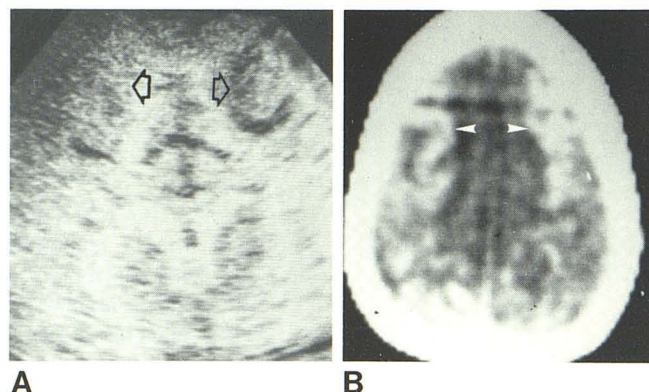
6-month-old infant with meningococcal meningitis. A, Ventricular enlargement and focal areas of cortical echogenicity most prominent on left (arrows). B, 1 week later. Bilateral contrast enhancement in cerebral cortex (arrowheads). Enhancement on right is more prominent than echogenicity on sonogram, possibly because of 1 week delay between studies.
